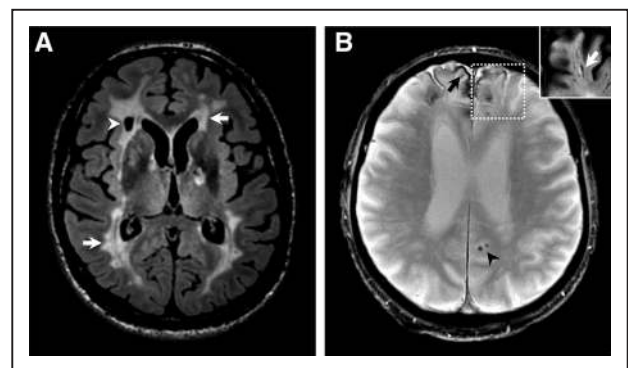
Magnetic resonance (MR) imaging changes associated with vascular cognitive impairment (VCI). A, Fluid-attenuated inversion recovery (FLAIR) image of a 64-year-old male patient with vascular dementia (VaD) showing extensive white matter hyperintensities (white arrows) and a lacune in the right frontal white matter (white arrowhead). B, T2*-weighted gradient echo scan of a 52-year-old female patient with VCI, demonstrating 2 microbleeds in the left occipital cortex (black arrowhead) as well as superficial siderosis in the frontal cortex predominantly on the right side (black arrowhead); inset: FLAIR image of the left frontal cortex displaying an enlarged perivascular space. In both cases, there is some indication of brain atrophy as reflected by a widening of sulci.
